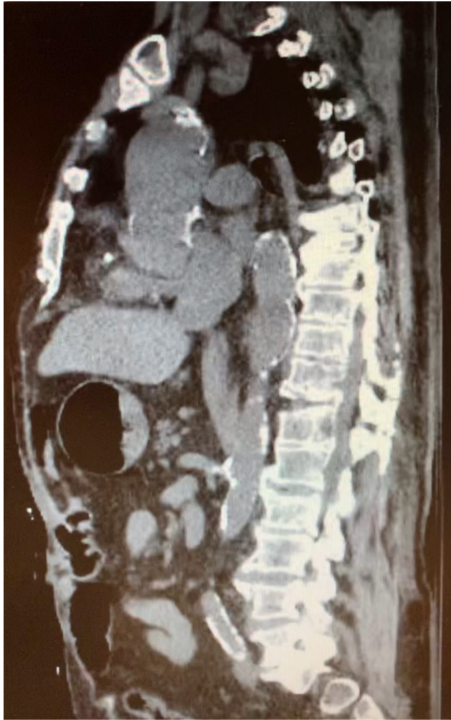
Spinal CT Scan showing fracture at D12.
